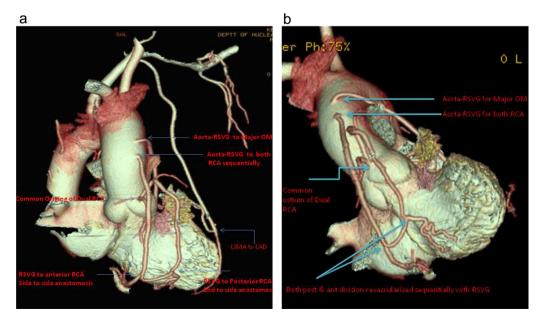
(a and b) Post-operative CT angiogram showing common origin of dual RCA, course of dual RCA in right AV groove, and two large PDA. It also demonstrates patent graft supplying both PDA sequentially.
